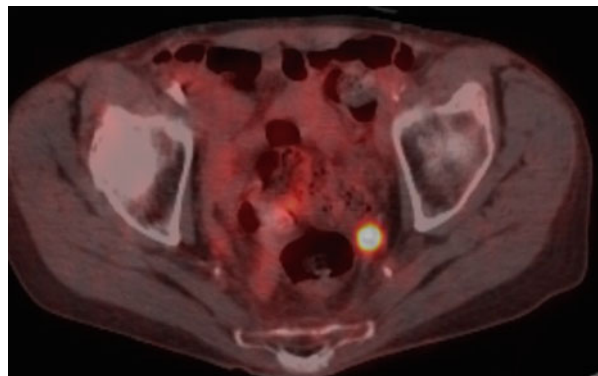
Fused axial PET-CT image shows FDG avid metastatic left perirectal lymph node
